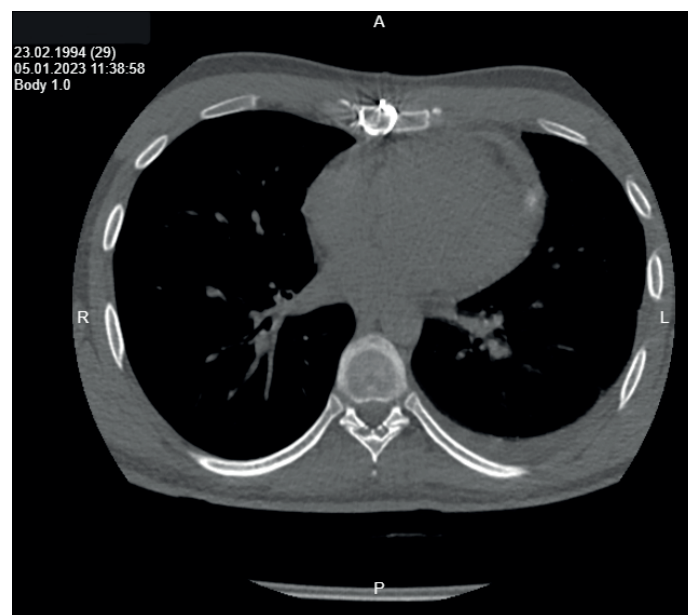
Computed tomography image taken at the emergency department admission after the surgery
